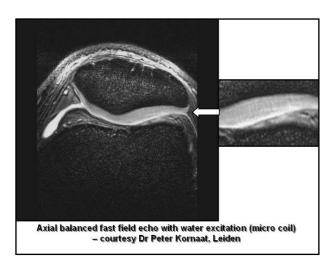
Normal hyaline cartilage anatomy shown by MRI. The magnified field shows the fine, normal detail within hyaline cartilage, including the recently described vertical striations and signal gradient reflecting hydration and hence proteoglycan concentration.
